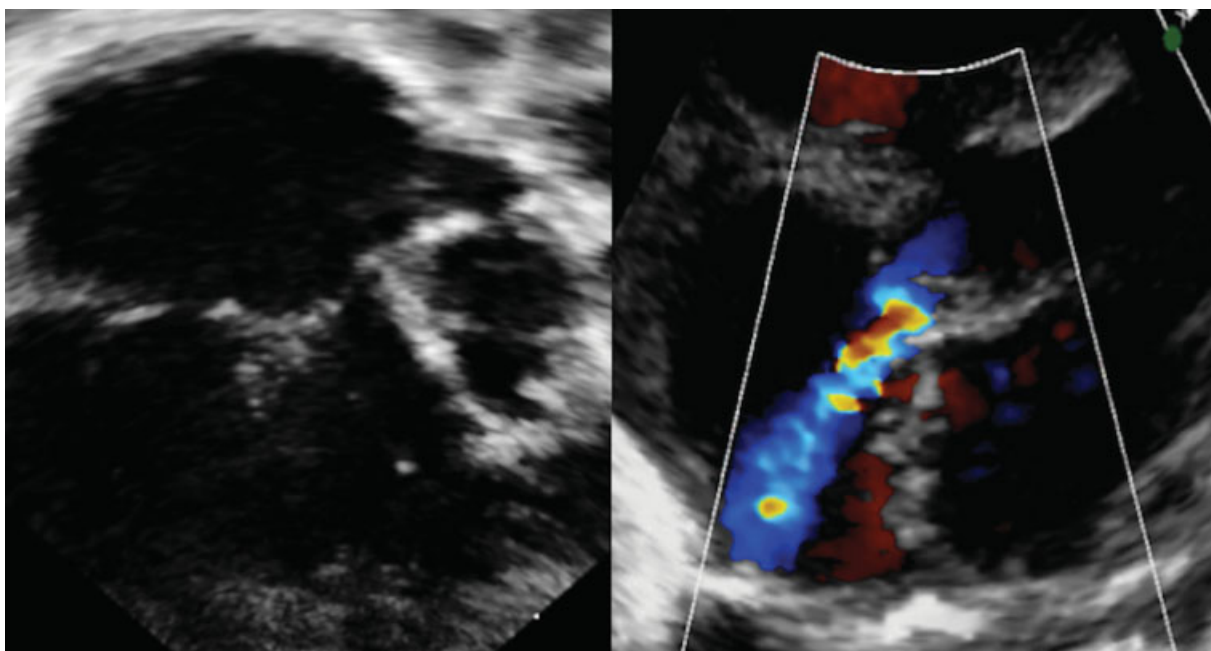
Fetal ECHO “4-chamber view” showing a hypoplastic left ventricle and left atrium (left) and color Doppler’s image showing aortic regurgitation (right).
